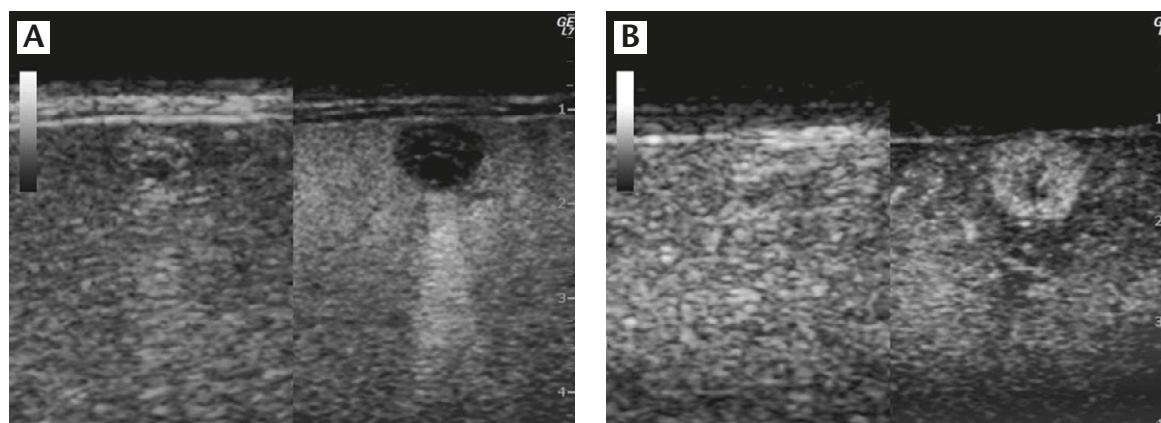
Hepatocellular carcinoma detected during screening of the entire liver. (A) Hepatocellular carcinoma detected during B-mode ultrasound (reference image) shows no clear nodules (left panel). However, Kupffer phase imaging at 11 minutes after intravenous injection of Sonazoid clearly shows Kupffer defects (right panel). (B) Reinjection of Sonazoid clearly shows arterial enhancement within the Kupffer defect (right panel).
